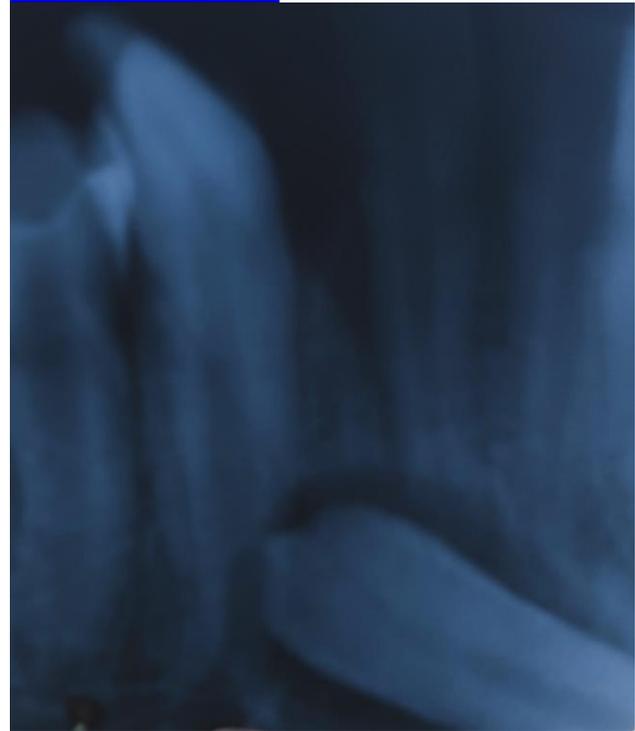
the orthopantomograph with periapical lesion in 42-44 region
